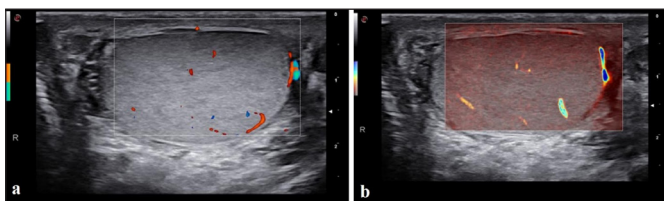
25 year-old patient who had formerly known COVID-19, (a) on color Doppler image (b) on Micro V Doppler imaging grade 2 parenchymal vascularity is seen.
